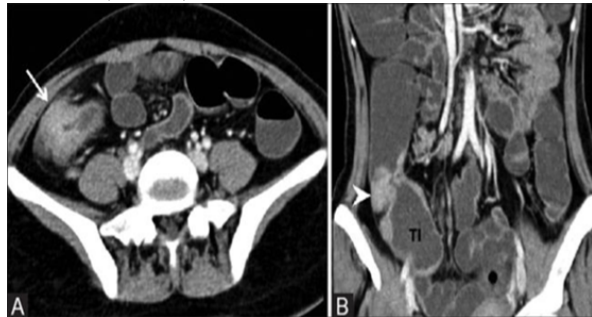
Axial (A) and coronal (B) CT enterography images show gross thickening of ileocecal valve (arrow) and contracted cecum (arrow head) with pericecal fat stranding. Terminal ileum (TI) is dilated proved to be Ileocecal tuberculosis.
